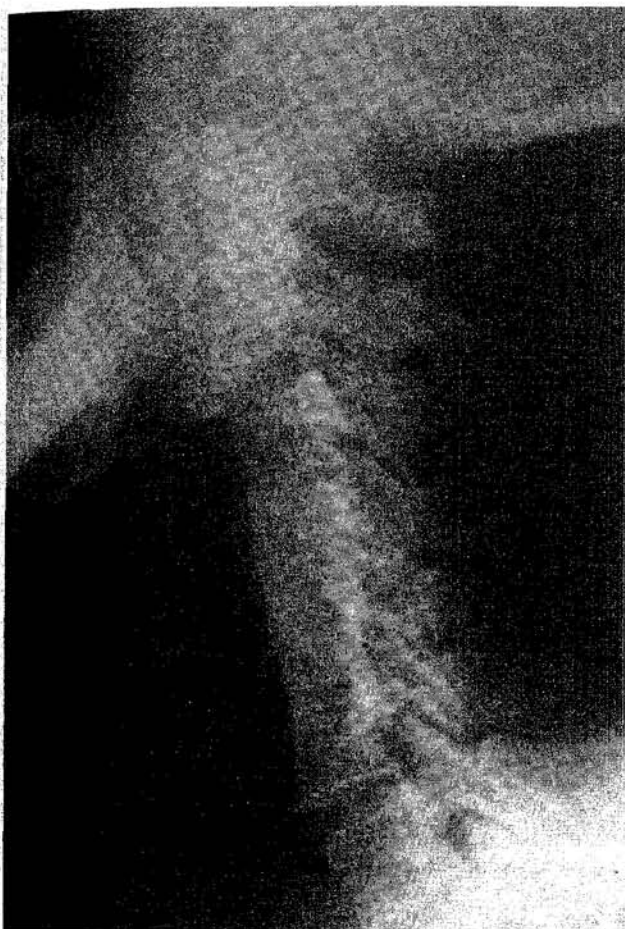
Lateral X-ray of 61-year-old man with CSM showing solid fusion from C3 to C6 levels four years after surgery. The symptoms were completely relieved post-operatively.
